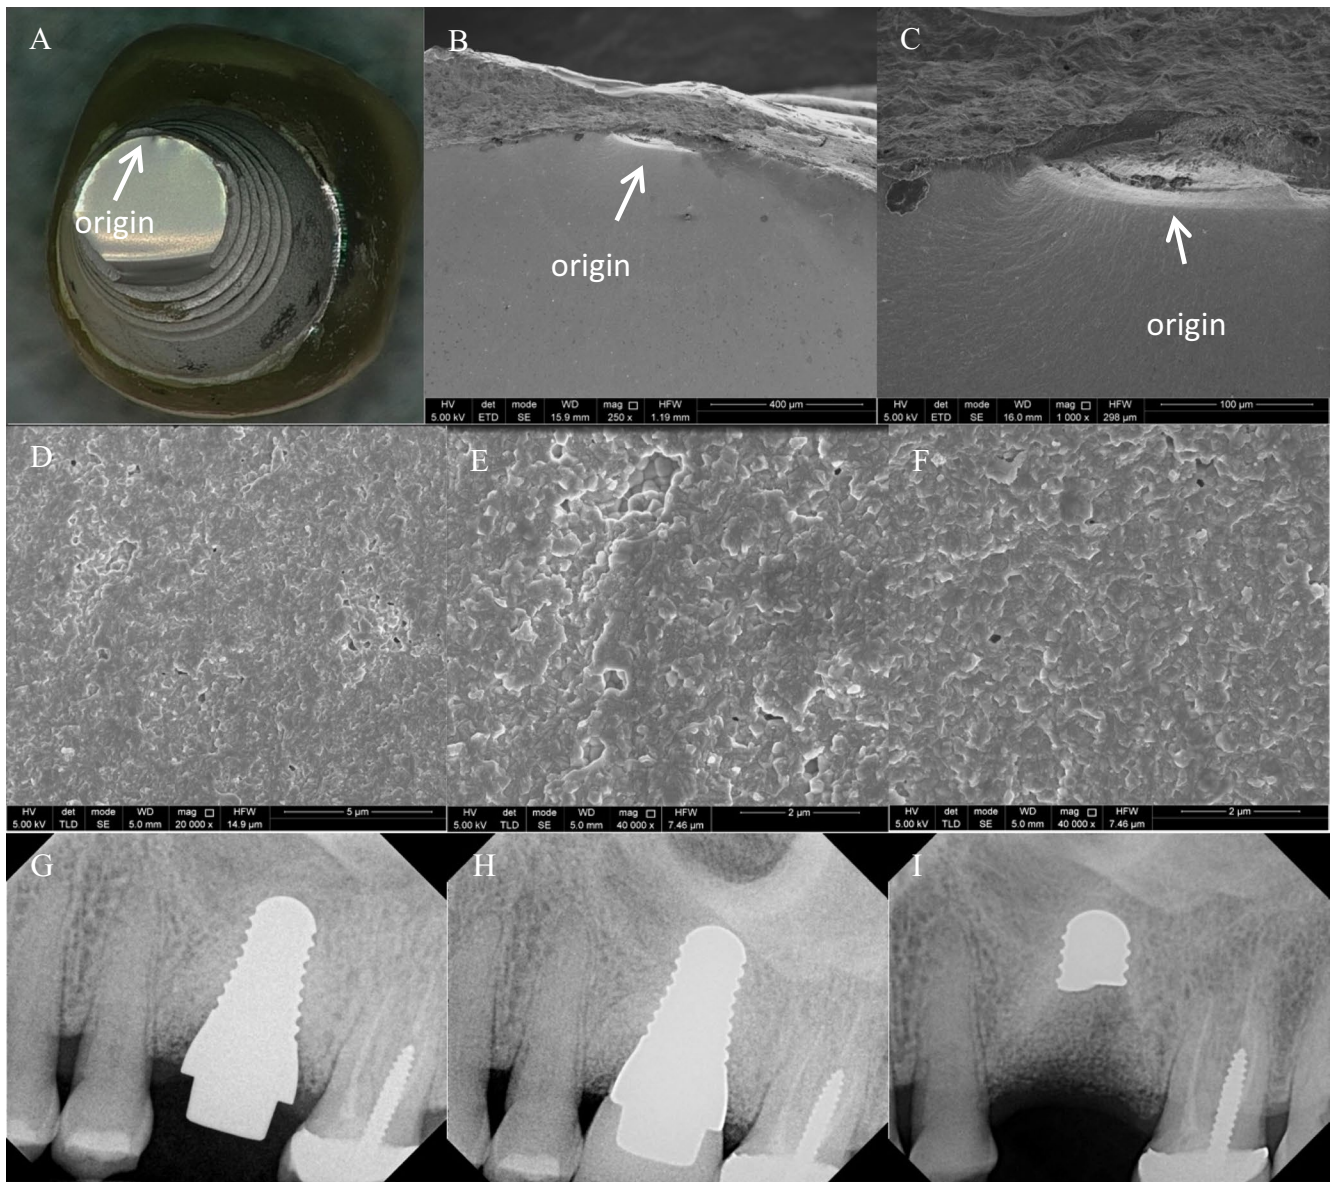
Fracture analysis of the CeraRoot implant. (A) Optical image of the fractured surface. (B) Chipping defect at the fracture origin. (C) Higher magnification of the chipping defect. (D–F) Fracture origin from high to low magnification demonstrating intergranular and transgranular fracture modes with visible pores. (G–I) Periapical radiographs at placement, at final restoration, and at removal.
